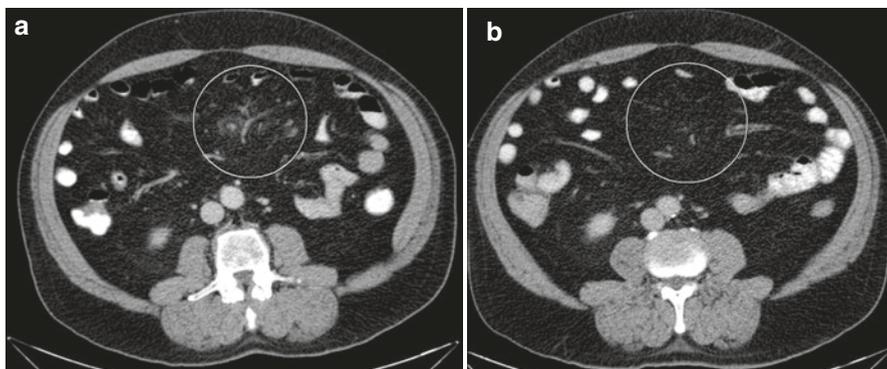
(a): Contrast-enhanced abdominal CT scan in a 64-year-old man with chronic pain in the lower left abdomen and postprandial diarrhea showing discrete sclerosing mesenteritis. (b): Follow-up CT scan after 4 months of tamoxifen treatment (20 mg b.i.d.) showing complete disappearance of intraabdominal abnormalities. His symptoms had resolved within 4 weeks of treatment
